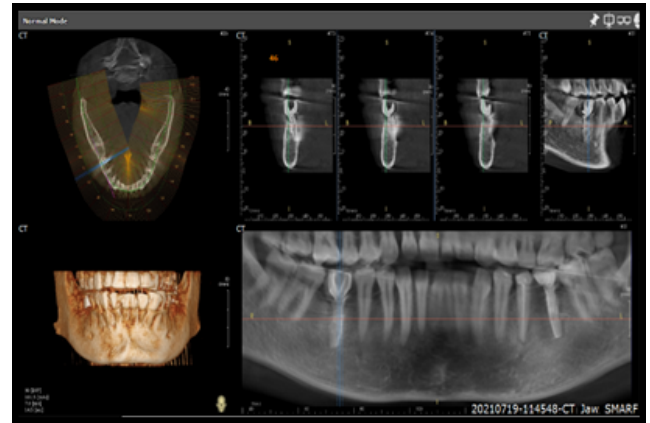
CBCT with Prosthesis in place
